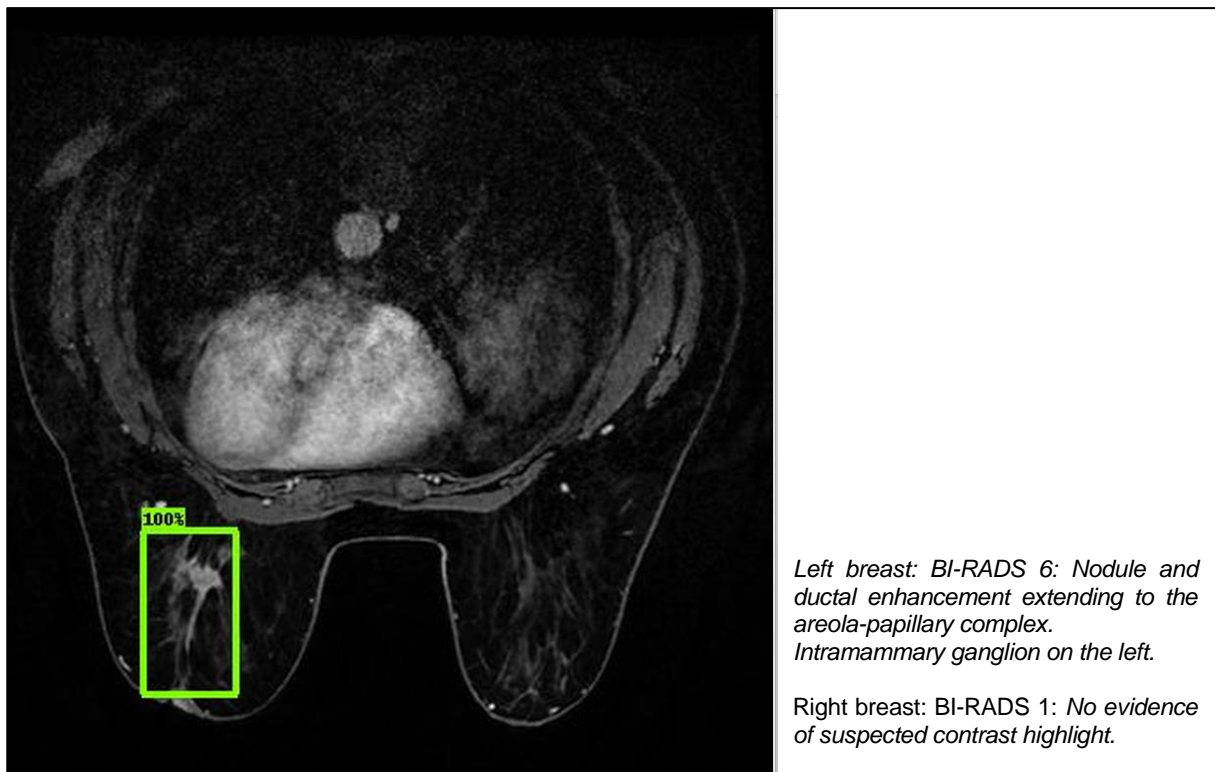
Patient 2 MRI detection results (findings) after applying the model B.
